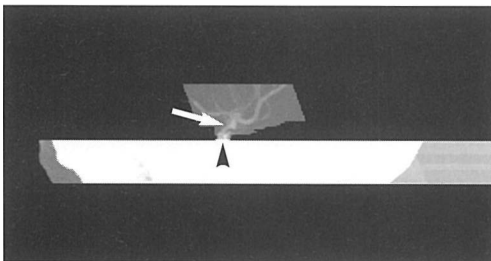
CT angiogram, maximum intensity projection, left anterior oblique view, demonstrates atherosclerotic stenosis of supraclinoid segment of left internal carotid artery (arrow) and extensive calcifications in this atherosclerotic lesion (arrowheads). Because of calcifications, angioplasty is contraindicated in this case.
